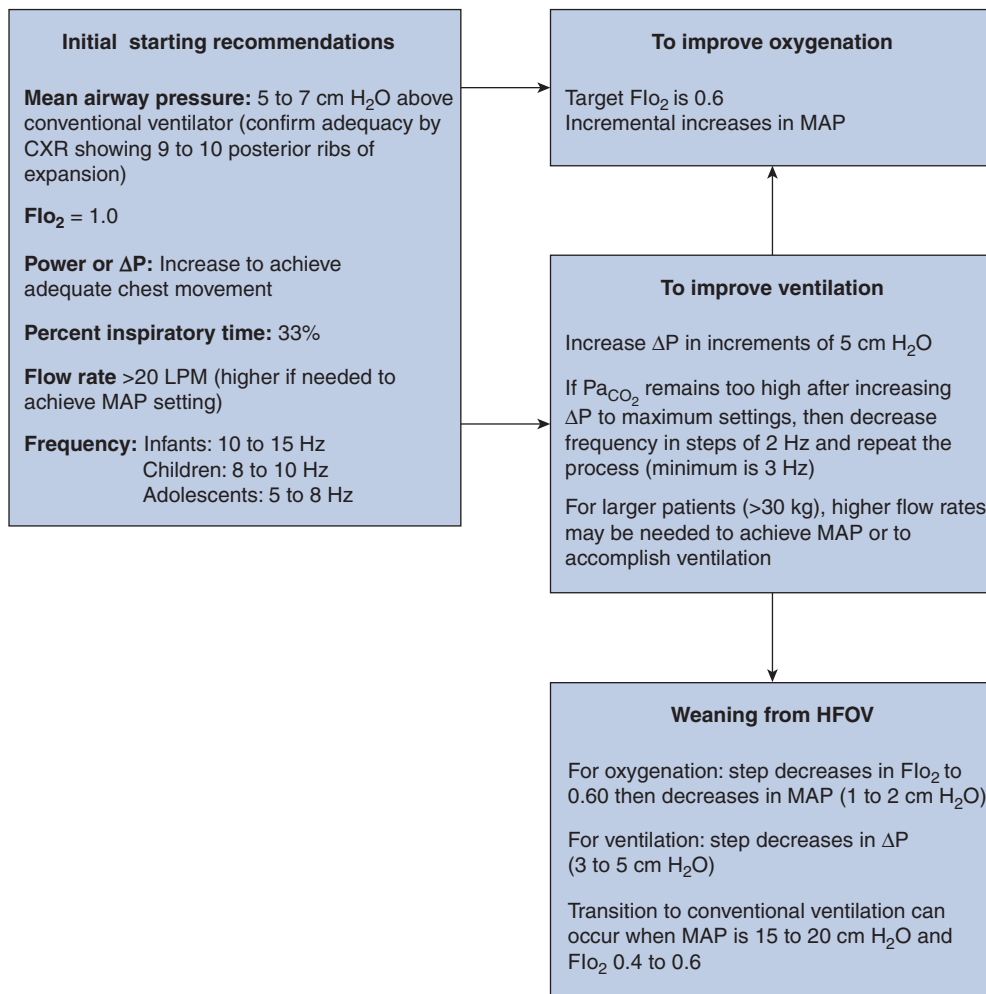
Recommendations for instituting high-frequency oscillatory ventilation (HFOV) and the transition to conventional ventilation during weaning. CXR, chest X-ray; LPM, liters per minute; MAP, mean airway pressure. (Courtesy Martha Curley, Children's Hospital Boston, Harvard Medical School. See also ref. 89.)
